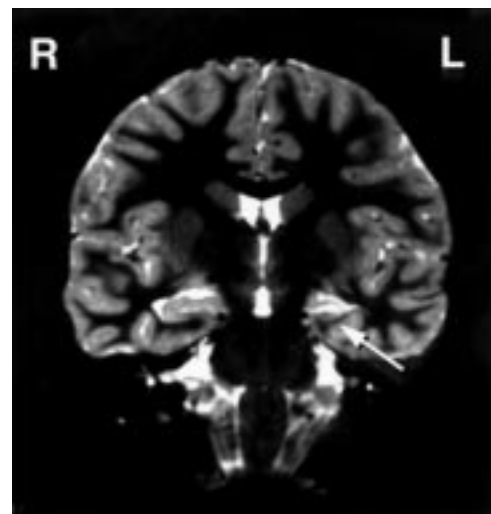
Coronal T<sub>1</sub> weighted MRI scan of the brain of an 8 year old girl. She had a prolonged focal febrile convulsion in the first year of life and later developed afebrile complex partial seizures, some of which were secondarily generalised. The arrow marks the left hippocampus, which is smaller than the right. For further details see text.
